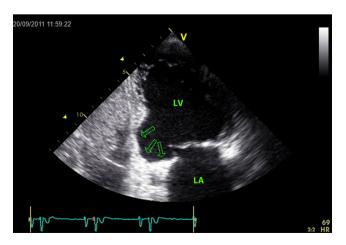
Aneurysm of the inferior wall (arrows) visualized by transthoracic echocardiography. LV = left ventricle, LA = left atrium.
